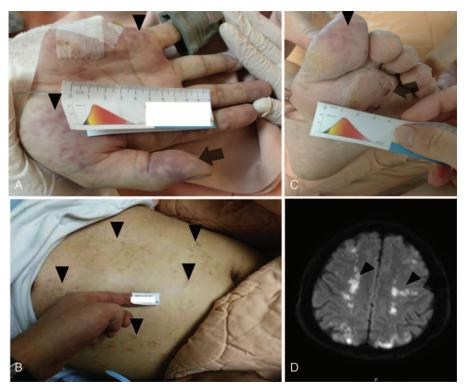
Hypereosinophilic syndrome (HES) complicated with diffuse brain and peripheral arterial embolizations. (A) Clinical photograph of the right palm showed erythematous papules and macules (arrowhead) over the right palm and livedo reticularis in the distal right thumb (arrow). (B) Clinical photograph of erythematous papules in the flank (arrowheads). (C) Clinical photograph of the right foot showed subcutaneous hemorrhage (arrow) over the left foot and purpura in the left toe (arrowhead). (D) Magnetic resonance imaging of the brain showed diffuse hyperintense signals from diffusion weighted image in bilateral cerebral hemisphere suggesting recent infarction (arrowheads). Similar embolic infarcts over bilateral cerebellum were also noted (not shown).
